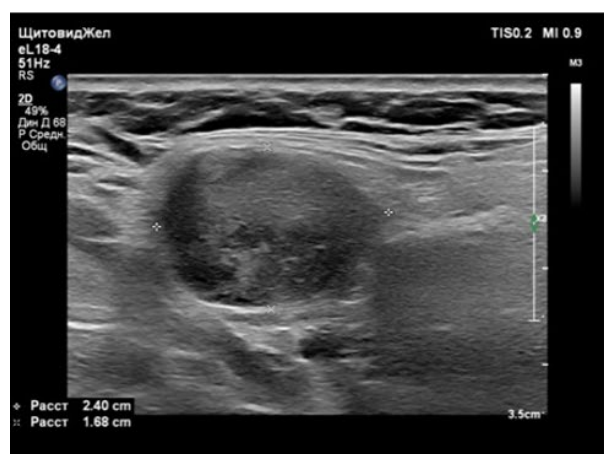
B-mode ultrasound image of lateral surfaces of the neck – hypoechoic lymph nodes, heterogeneous echostructure, 1.3–2.4 cm in size.
